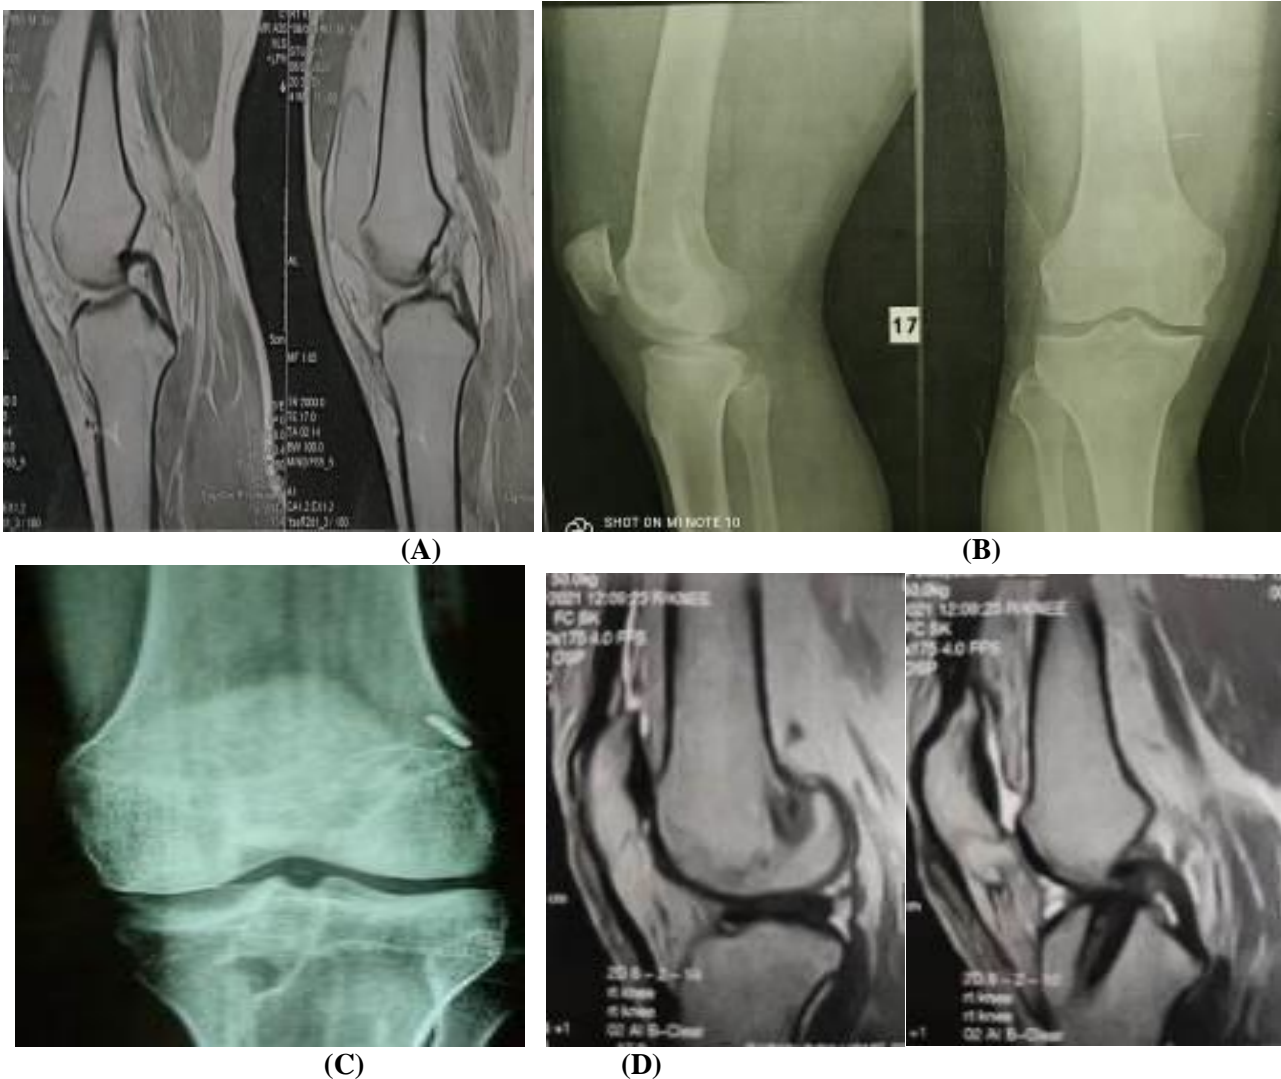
A 41 years old male, who is a teacher, complained of recurrent giving way of right knee following indirect twisting knee trauma during sport 24 months preoperatively he sought medical treatment but didn't improve. A) Preoperative X-ray AP and lateral views. B) Sagittal MRI, C) X-ray showing position of the femoral and tibial tunnel, D) Postoperative Sagittal MRI.
